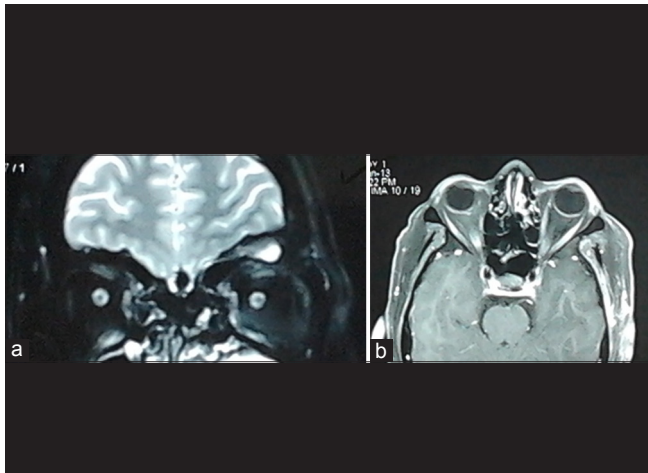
Two months postoperative magnetic resonance imaging photograph showing postoperative changes and granulation tissue with complete excision of the dermoid. There is no evidence of residual lesion
